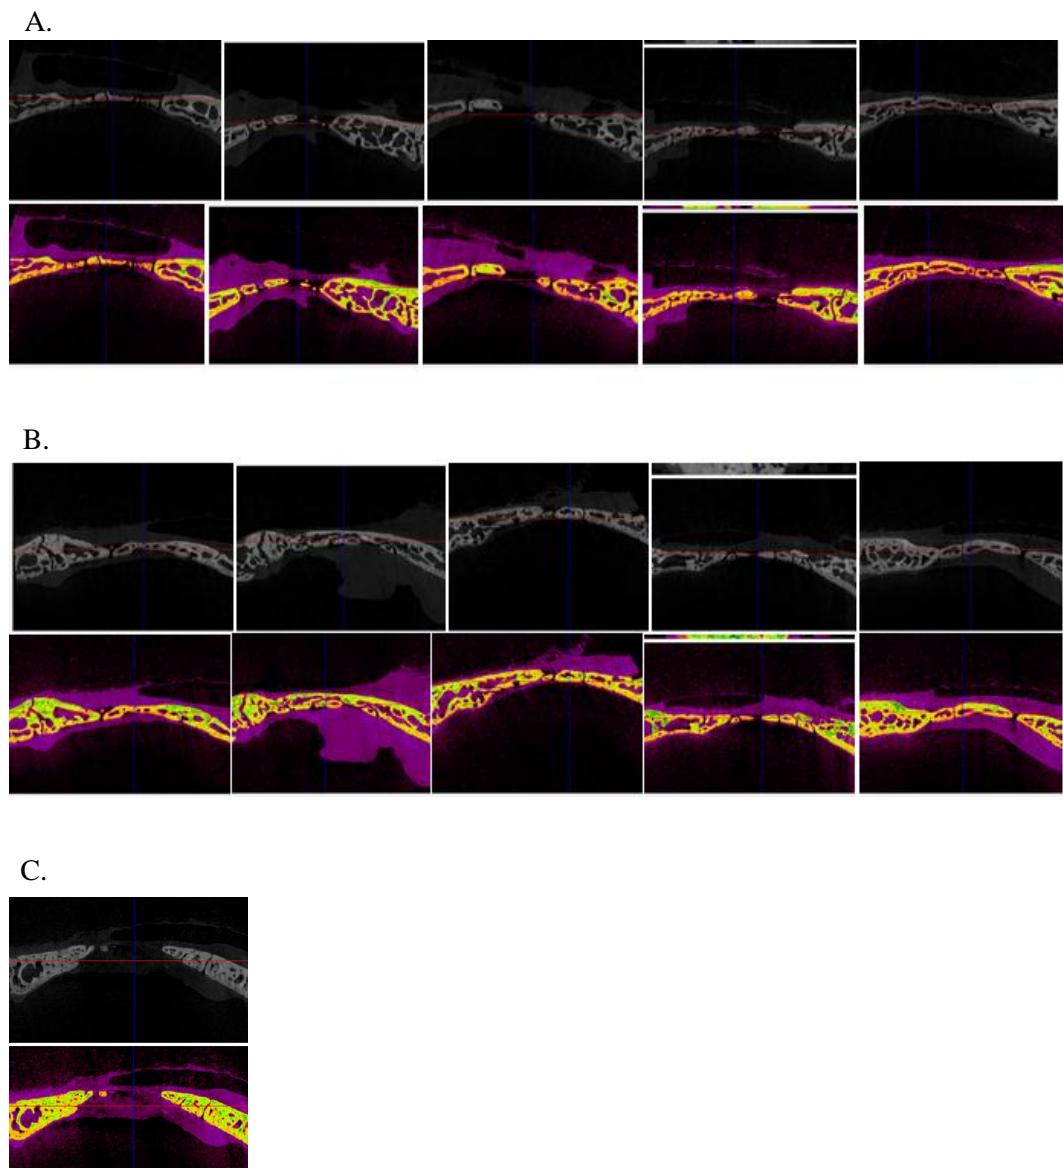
Micro CT images of collagen applied defects at 8 weeks. A. Collagen alone applied defects. B. Collagen+TAT-BMP-2 5 μ g applied defects. C. Collagen+TAT-BMP-2 2 μ g applied defect.
